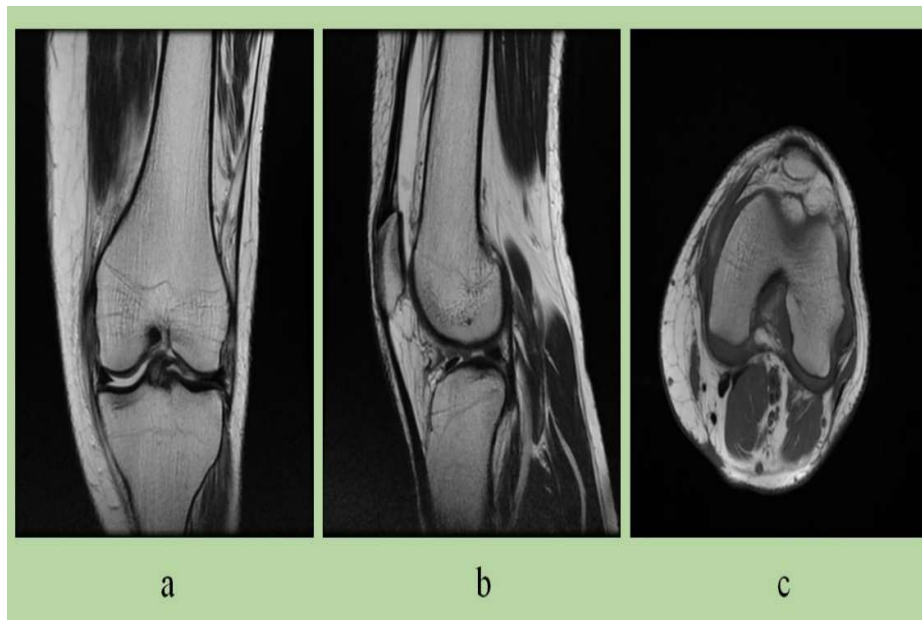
Knee MR image views (a) Coronal view (b) Sagittal view (c) Axial view
